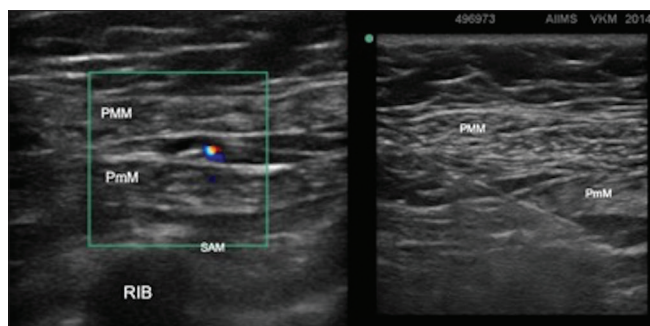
Sonoanatomy of PECS block with color Doppler showing pectoral branch of thoracoacromial artery (left) and PECS II block (right) [PMM - pectoralis major muscle, PmM - pectoralis minor muscle, SAM - serratus anterior muscle]
